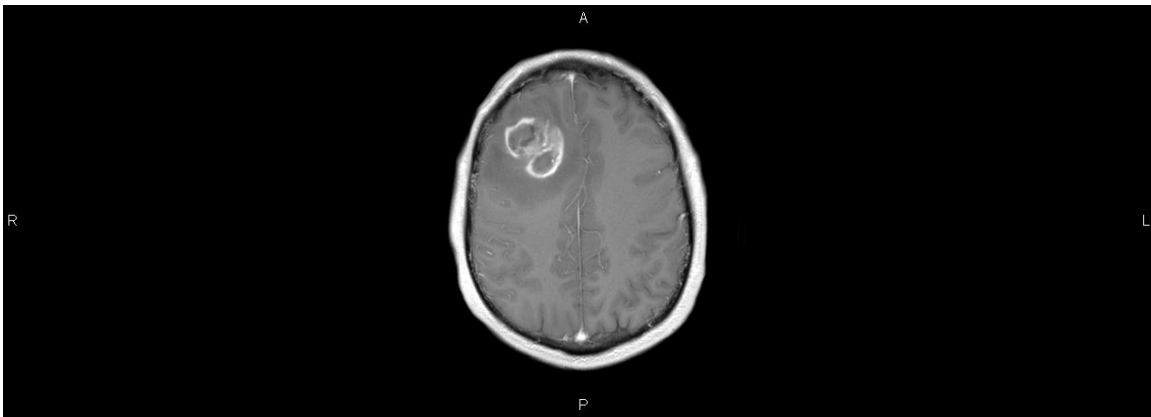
Axial Gadolinium enhanced T1W MRI. Frontal lobe lesion with peripheral irregularly enhancing rim.
